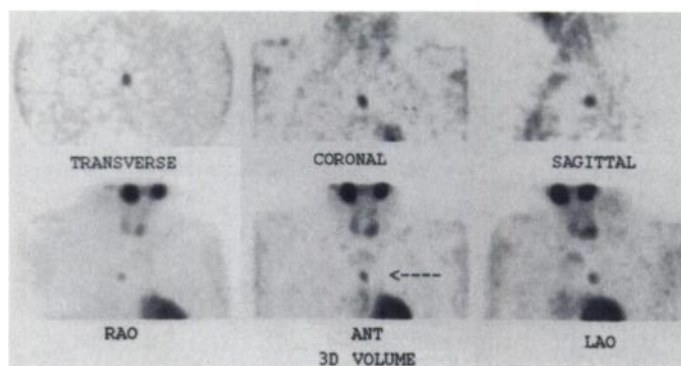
SPECT images clearly demonstrate an abnormal focus (arrow) in the middle mediastinum.
